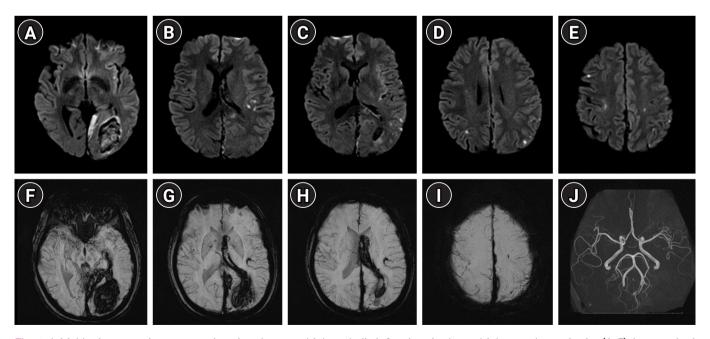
Initial brain magnetic resonance imaging shows multiple embolic infarctions in the multiple vascular territories (A-E). Intracerebral hemorrhage in the left occipital lobe and adjacent intraventricular, subdural and subarachnoid hemorrhages are also observed on susceptibility-weighted images (F-I). No significant vascular derangement is seen on the magnetic resonance angiography (J).
